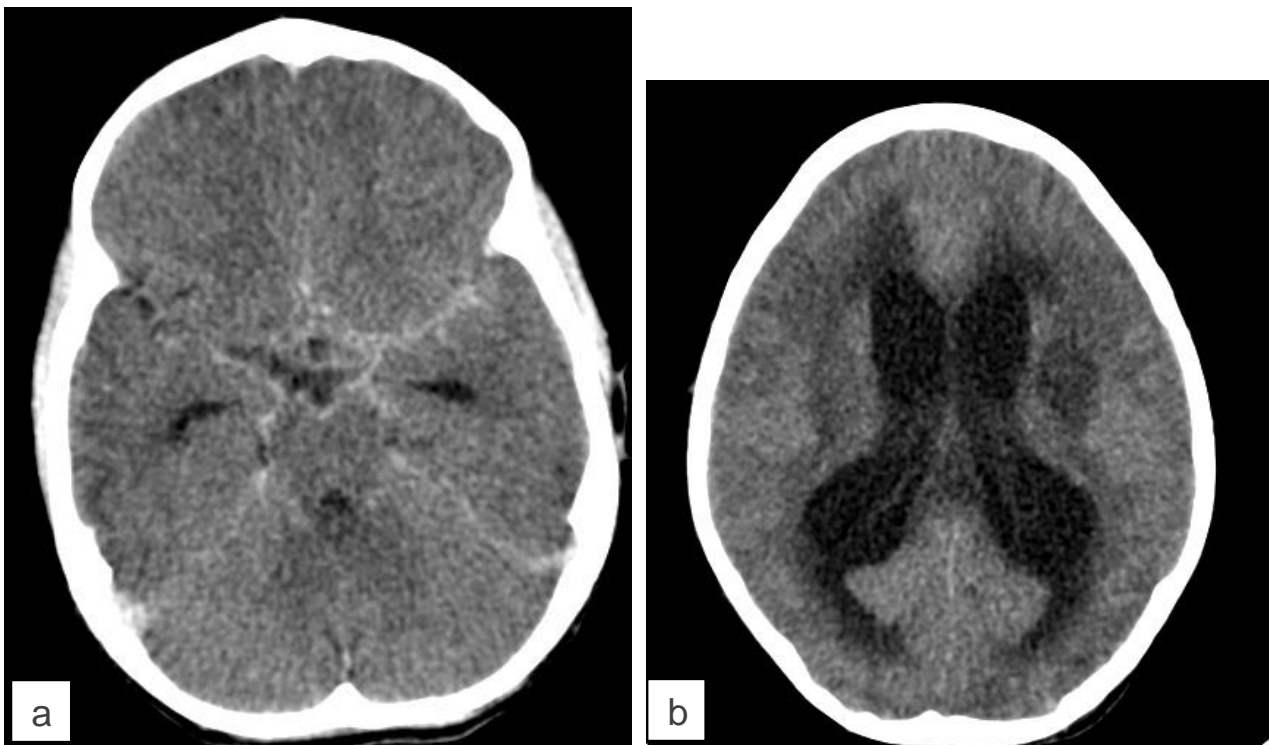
(a) CT brain of a child with TBM showing basal meningeal enhancement. However, TBM imaging may be atypical with the usually typical signs absent or more subtle. (b) CT brain of the same child as above with TBM, showing hydrocephalous and basal ganglia infarct.
